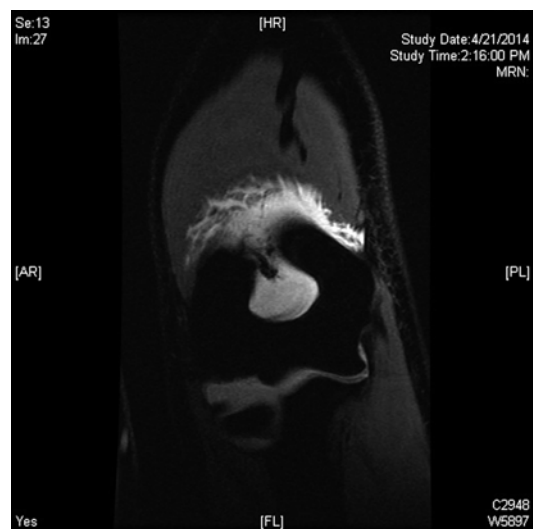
A magnetic resonance imaging study with dye provides the most accurate imaging of the ligaments of the elbow
